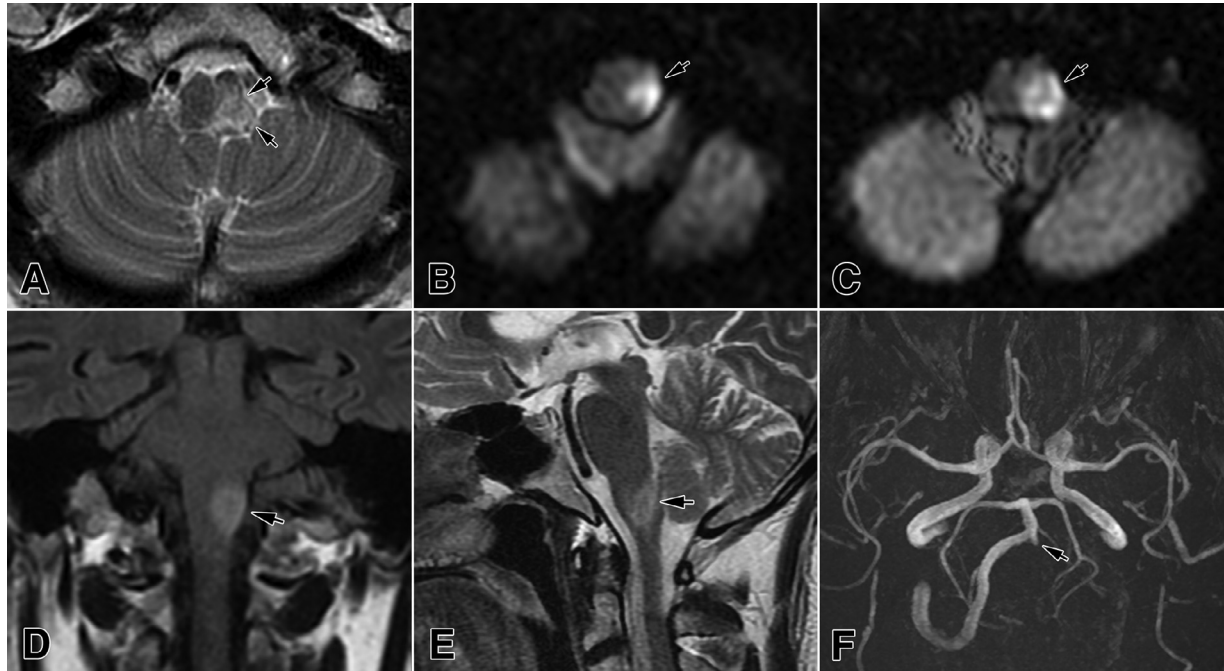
A left incomplete medial, anterolateral, lateral, and dorsal infarction (arrows) of the lower, middle and partially upper medulla, presented in the axial T2-weighted (A) and DWI (B and C) images, as well as in the coronal FLAIR (D) and T2-weighted sagittal (E) sections. The MRA shows an occlusion (arrow) of the left vertebral artery (F).
